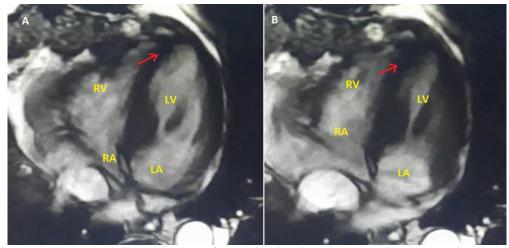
Cardiac MRI 4 chamber view shows the left ventricle in diastolic phase (A) and systolic phase (B) revealing severe dysfunction of the apex (red arrows). LV: left ventricle, LA: left atrium, RV: right ventricle, RA: right atrium
